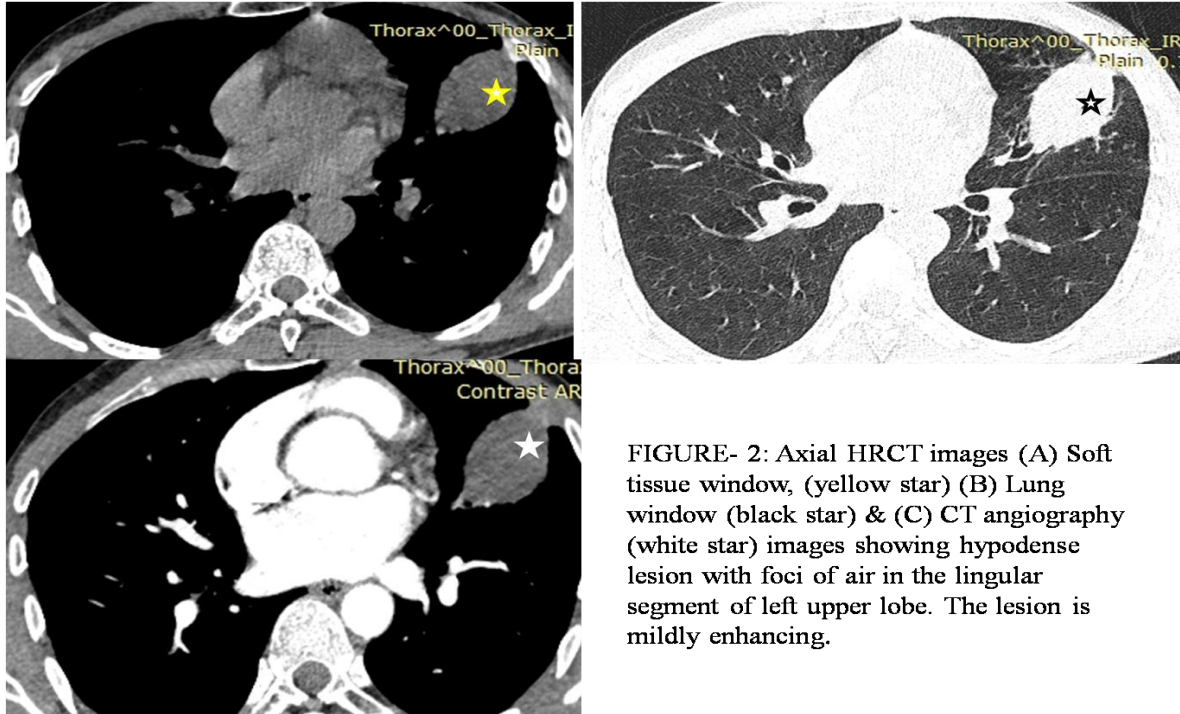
Axial HRCT images (A) Soft tissue window, (yellow star) (B) Lung window (black star) & (C) CT angiography (white star) images showing hypodense lesion with foci of air in the lingular segment of left upper lobe. The lesion is mildly enhancing.
